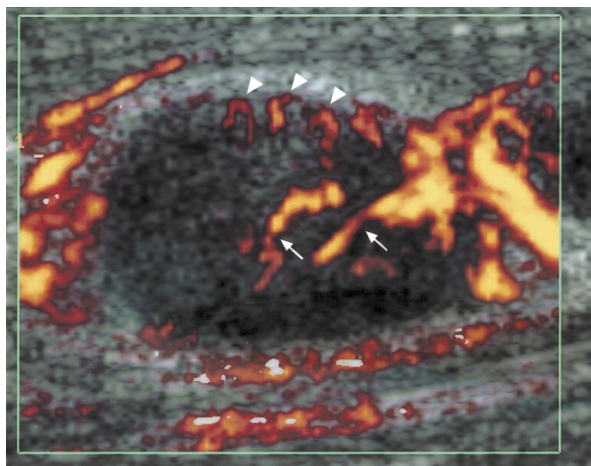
Power Doppler sonogram of a malignant node with both hilar (arrows) and peripheral (arrowheads) vascularity.
